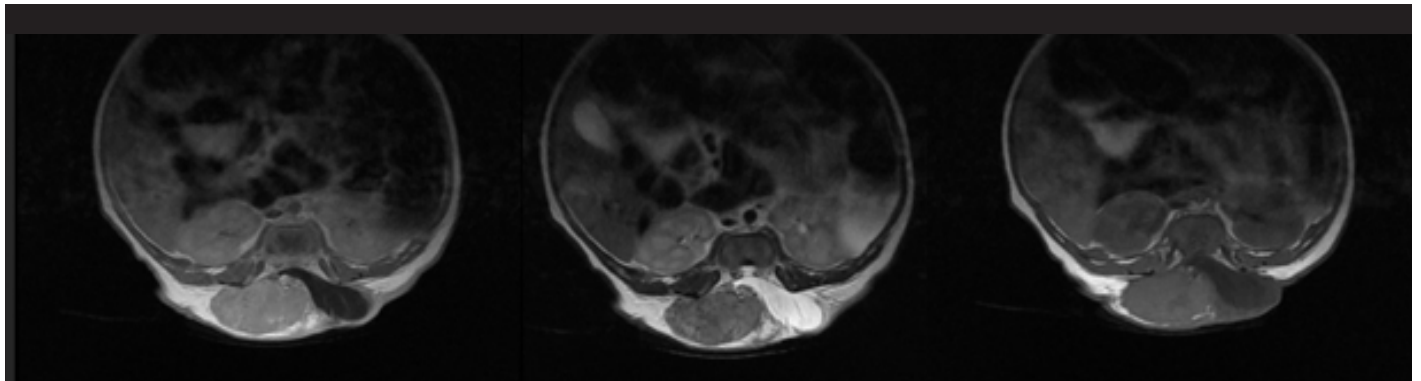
MRI image of the case
